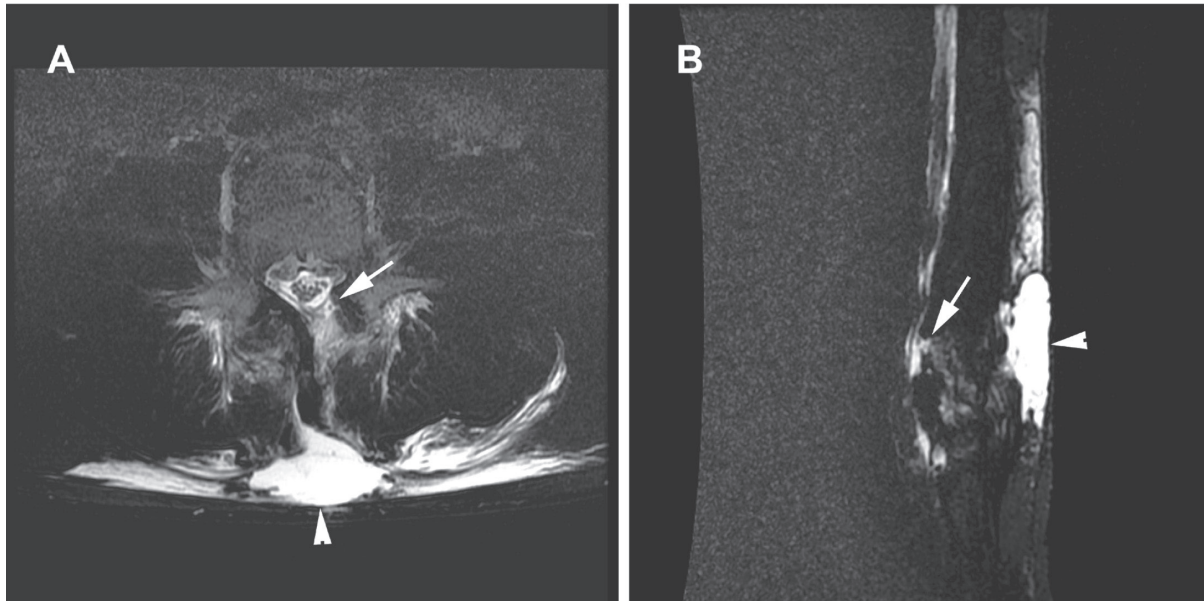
Examination of the lumbar spine with (A) T2-weighted fat-suppressed magnetic resonance imaging (MRI) (cross-sectional view), and (B) heavily T2-weighted MRI (sagittal view) revealing a large subcutaneous fluid collection (arrowheads) and small epidural effusion (arrows) with a signal intensity identical to that of cerebrospinal fluid, suggesting the diagnosis of pseudomeningoceles.
